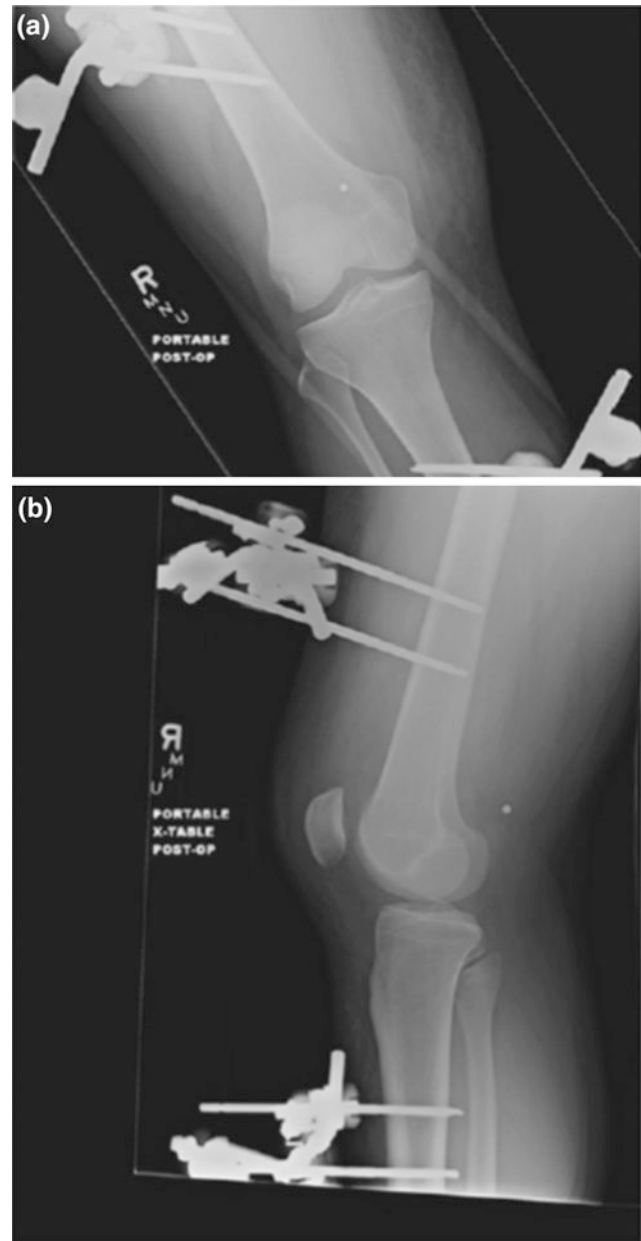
AP (a) and lateral (b) radiographs of a spanning external fixator placed for an unstable knee dislocation. Note the proper tibiofemoral reduction after ex-fix placement
